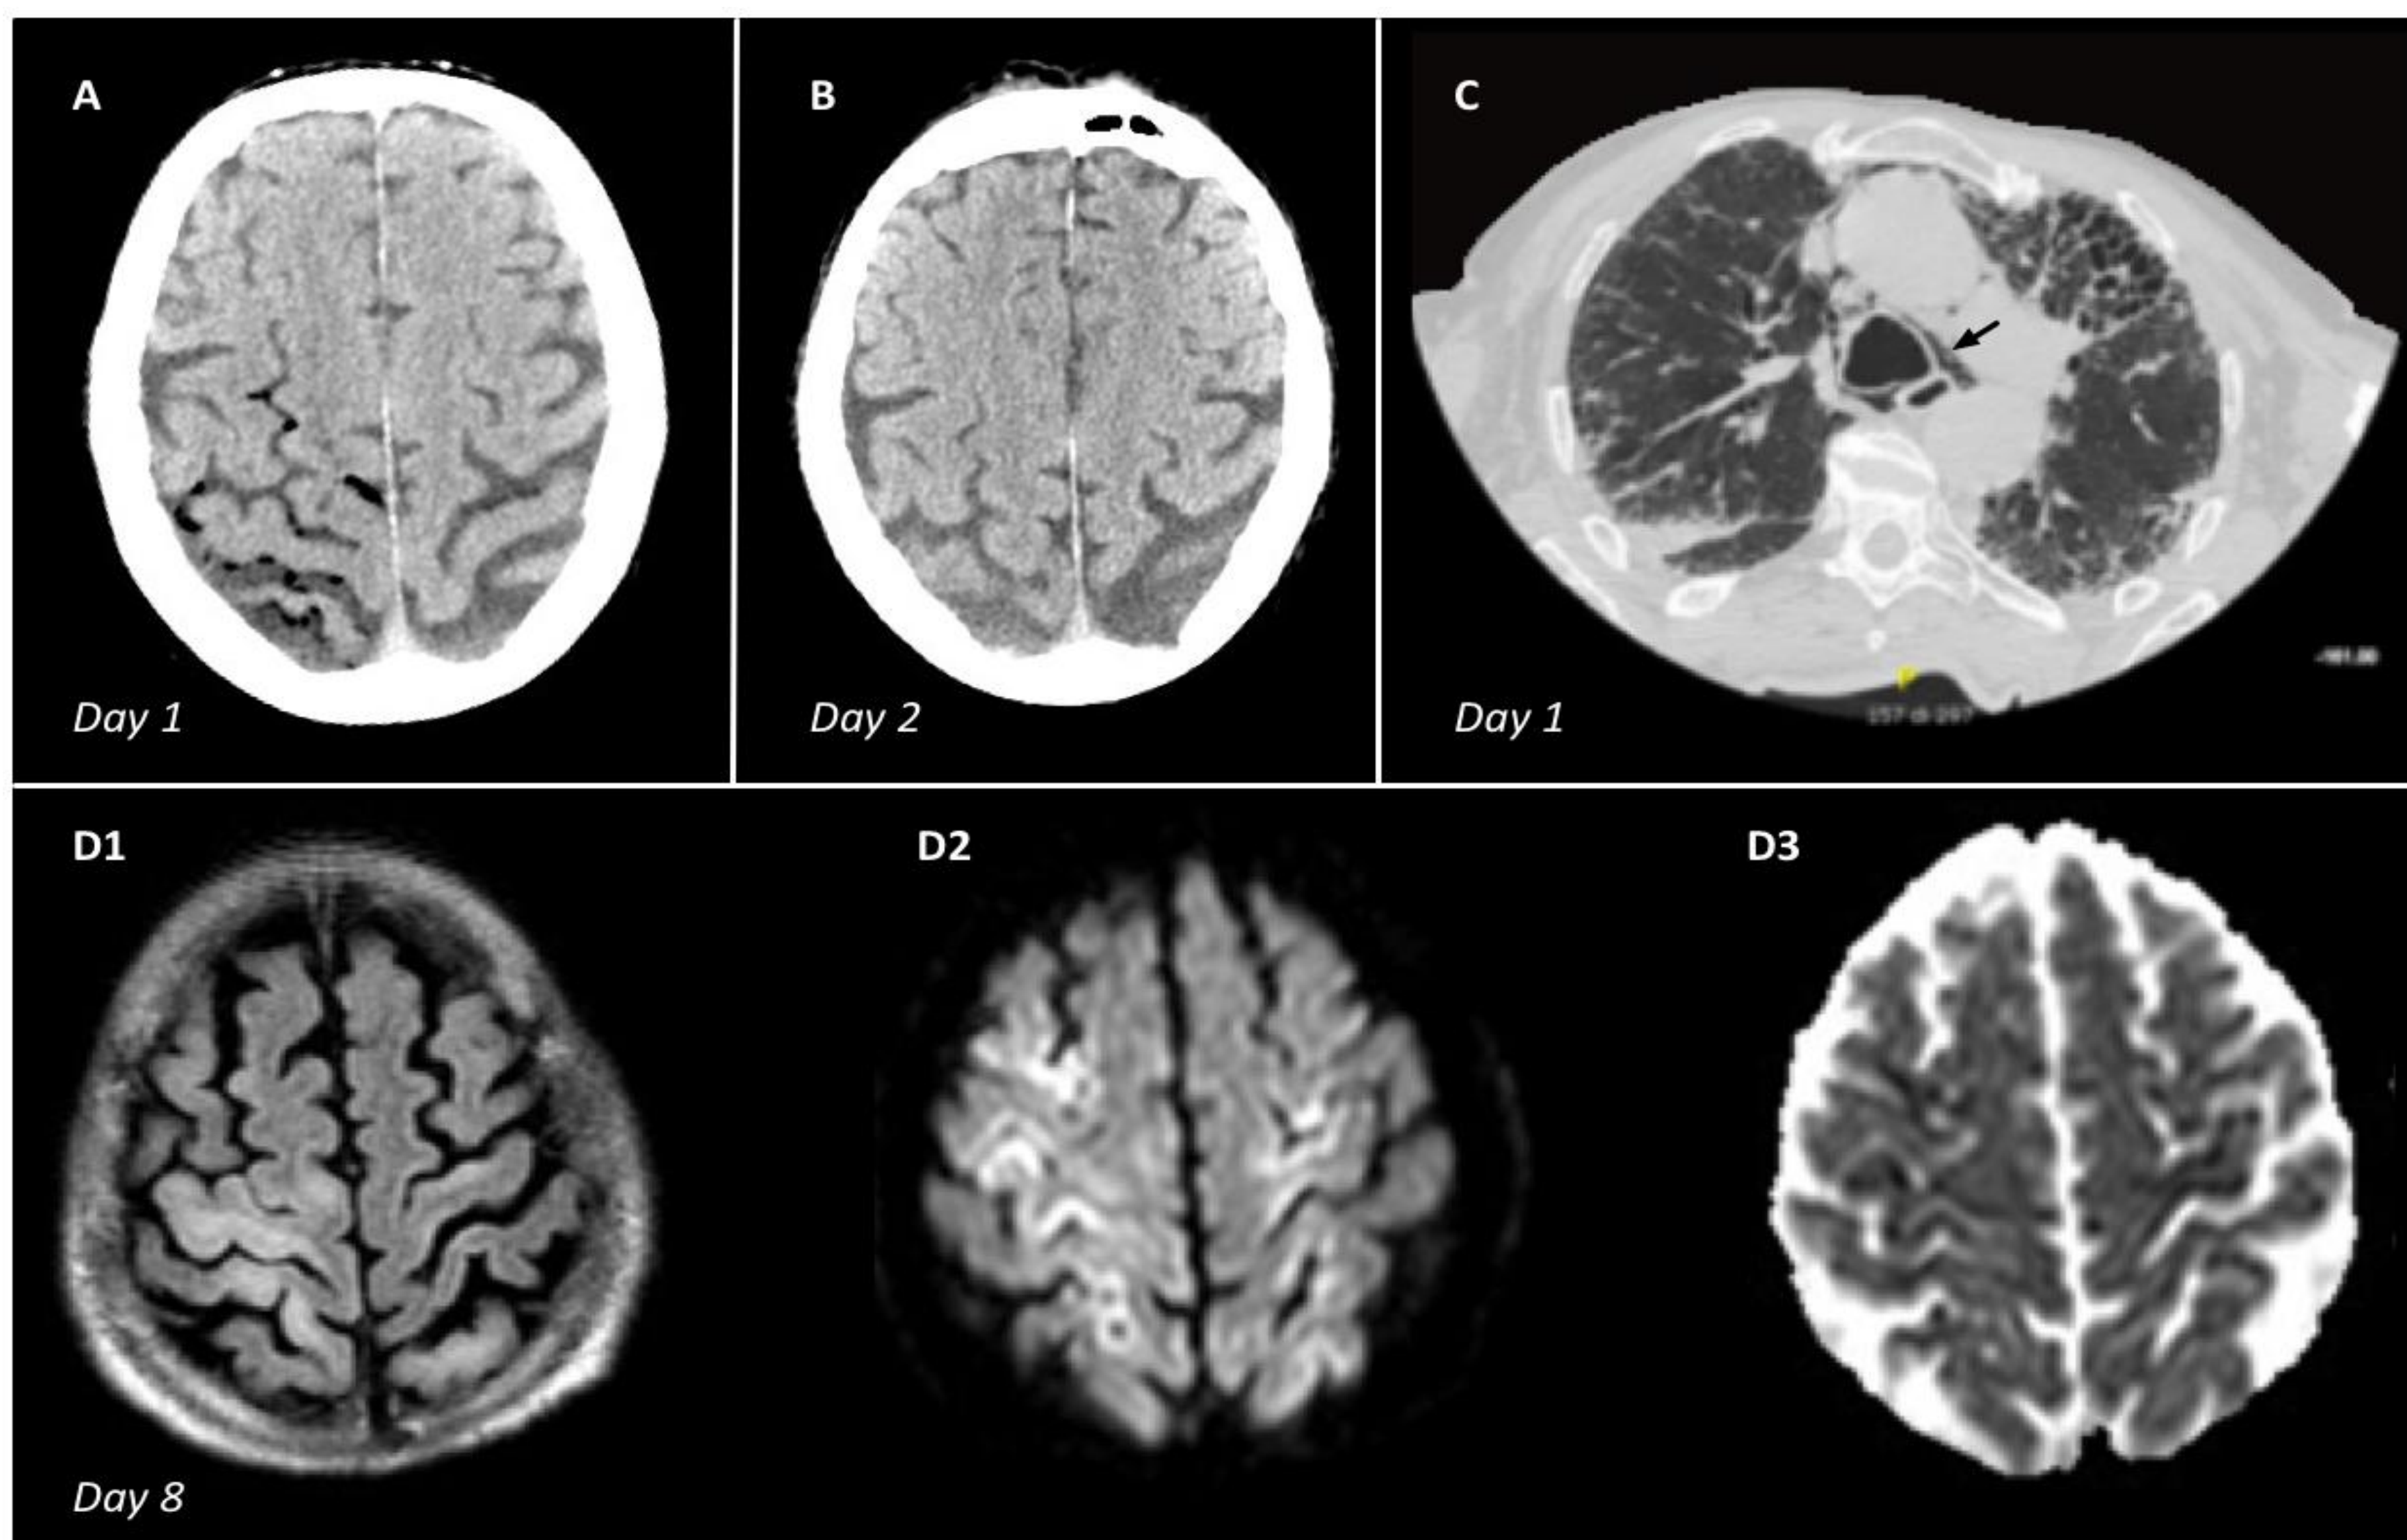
(A) Head CT scan performed on day 1. (B) Head CT scan performed on day 2. (C) Chest CT scan performed on day 1 showing pulmonary fibrosis, bronchiectasis and pneumomediastinum (arrow). (D1-D2-D3) Brain MRI performed on day 8: (D1) FLAIR imaging of magnetic resonance; (D2) DWI imaging; (D3) ADC imaging.
